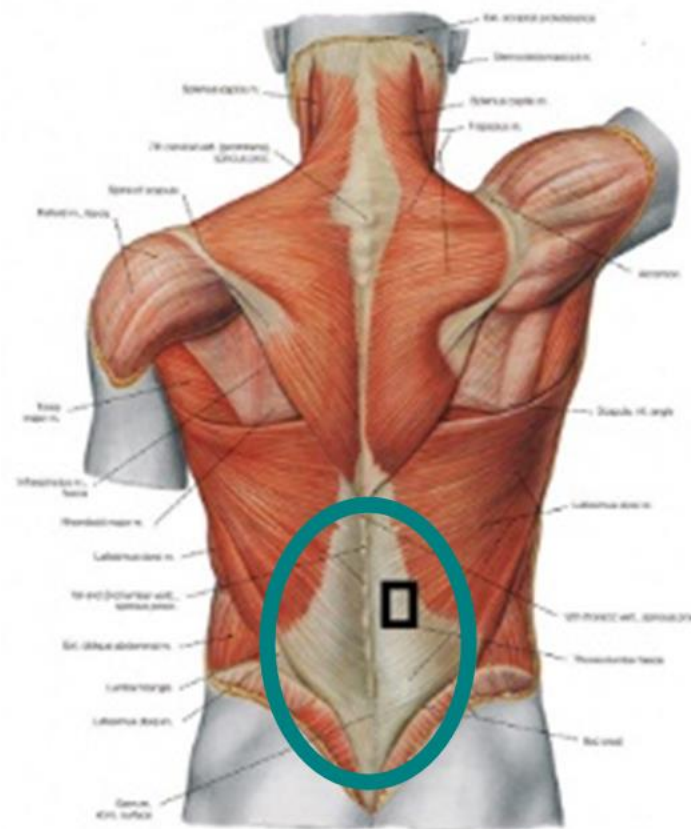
Position of ultrasound image collection 2cm laterally of the L2—3 intervertebral disc space and the thoracolumbar fascia (Gray, 1918).
